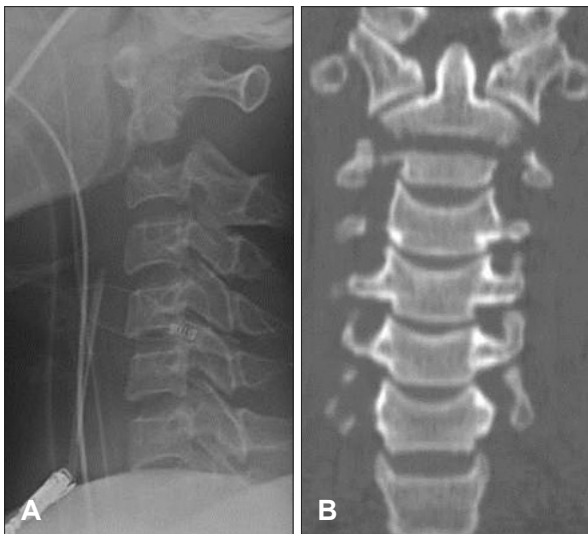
Lateral cervical radiography (A) and computed tomography with 2D coronal reconstructions (B) revealing vertical displacement of axis greater than 5 mm.
